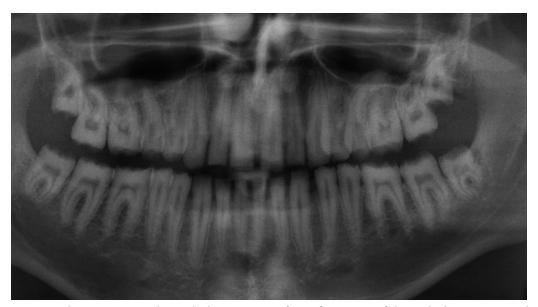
The panoramic radiograph shows a severe form of AI. None of the teeth show any enamel coverage.
